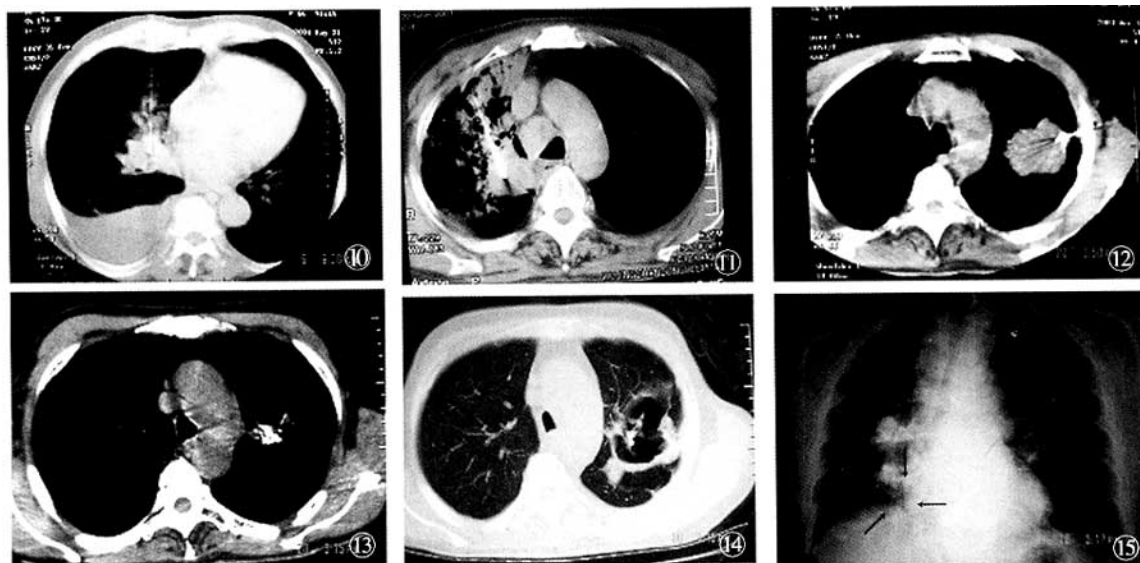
The central type lung cancer at the inferior lobe of the right lung accompanied by metastases at the anterior superior mediastinum, manubrium of the sternum and the right anterior upper breast: the CT guided percutaneous implantation of ^{125}I radioisotopes was conducted again.
